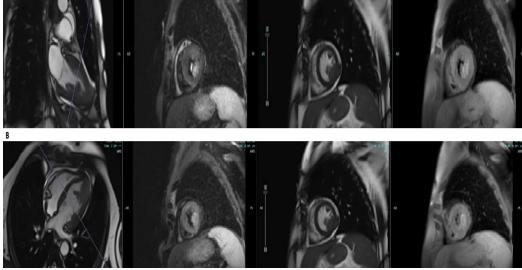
Cardiac MRI: (A)In the inferior-lateral wall of the left ventricular apex, there is a 30x20 mm solid mass lesion that is isointense with the myocardium on T1. (B) Slightly hyperintense on T2, shows no contrast enhancement in the early phase, and exhibits similar contrast enhancement to the myocardium in the late phase, protruding towards the lumen. These findings are primarily suggestive of metastasis.
